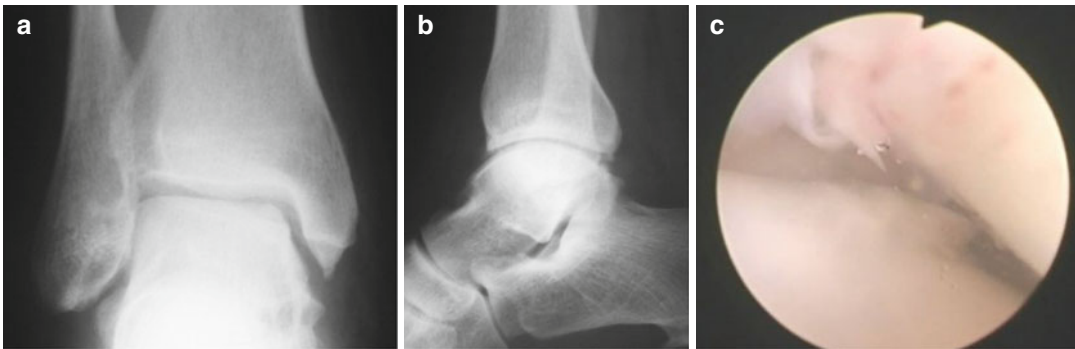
(a–c) Early onset of osteoarthritis – X-ray and arthroscopic view
